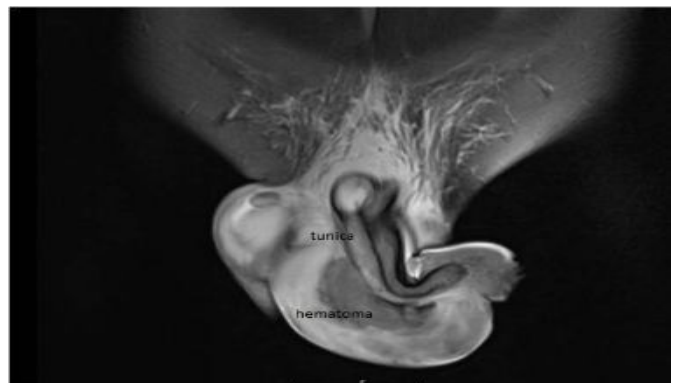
MRI revealing penile fracture as discontinuity of the linear black signal of tunica albuginea and hematoma.
